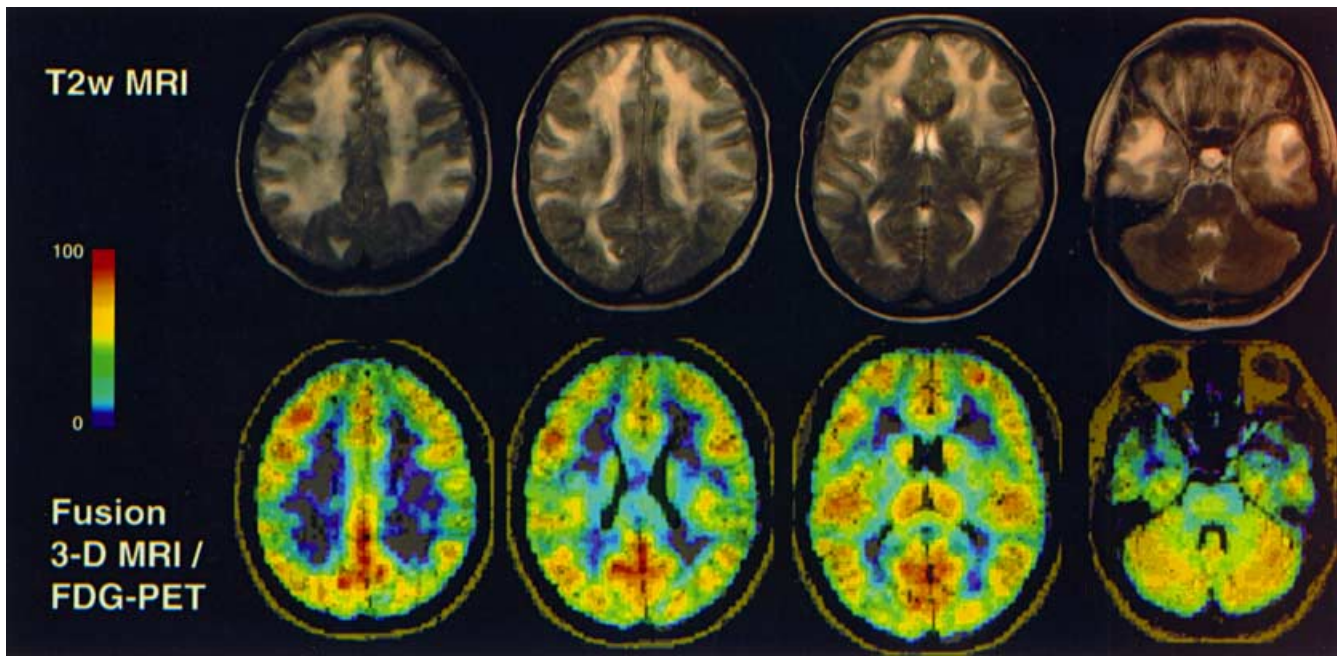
T2-weighted MRI scans (*T2w MRI*) showing diffuse hyperintensities in the white matter of both hemispheres, and fusion MRI/FDG-PET revealing generalized hypometabolism in corresponding areas
